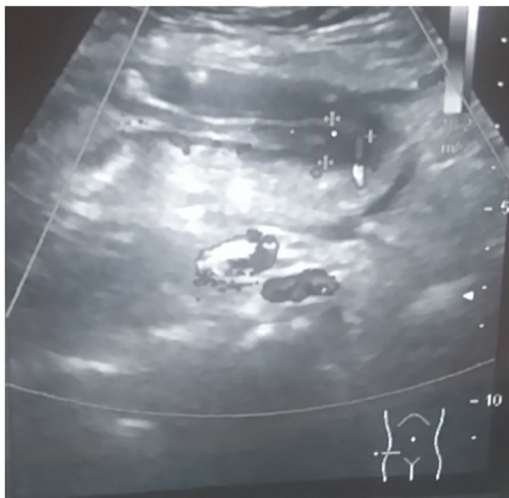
Abdominal ultrasound is showing the appendix between the marks with peri-appendicular edema.
